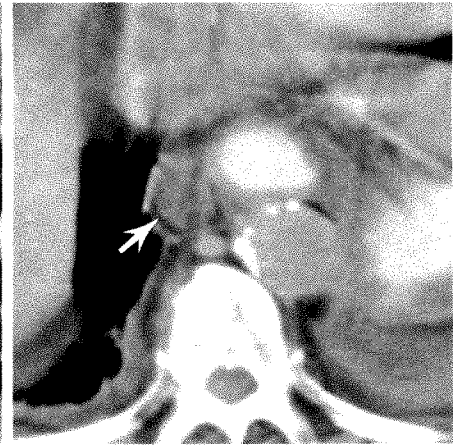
Case 1: Metastatic ovarian carcinoma. Contrast-enhanced CT scan shows extension of ascitic fluid (white arrows) into mediastinum with displacement of contrast-filled esophagus (open arrow) to right and indentation on posterior wall of inferior vena cava (black arrow-head). Ascites is visible below diaphragm bilaterally. Lower sections showed hiatal hernia and continuity of mediastinal fluid with ascites in abdomen.
